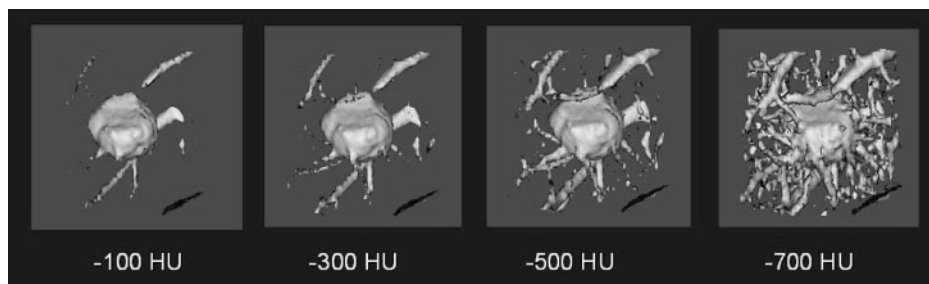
Example of a single nodule as it appears above different Hounsfield thresholds: the vascular connectivity increases with decreasing Hounsfield threshold (surface renderings, CT data: 0.8 mm slice spacing, 1 mm slice thickness).
